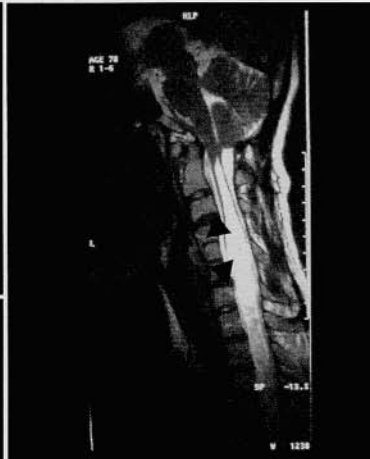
Syringa (fluid-filled cavity in the central part of the cervical cord) appears as hyperintense signal (black arrowheads) on MRI (T2-weighted sequence).
